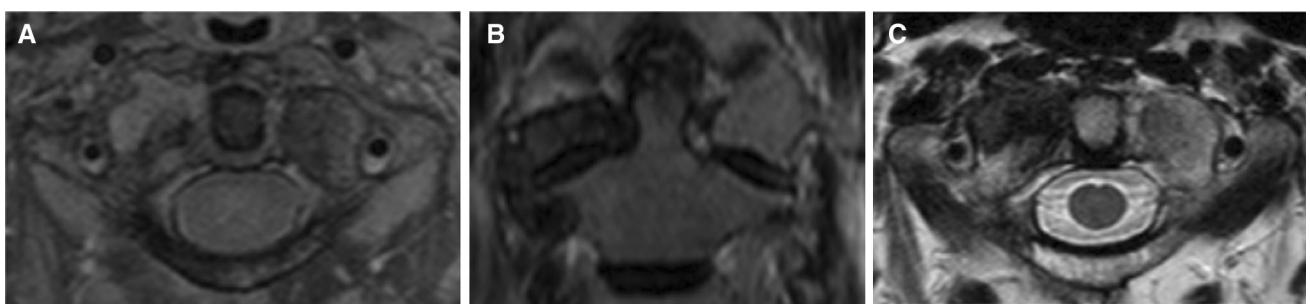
18 months post-biopsy MRI—a axial T1W_SPIR with gadolinium, b coronal T2W_TSE and c axial T2W_TSE_DRIVE: stable C1–C2 right lateral mass, arch and facets lesion regarding its dimensions and imaging characteristics
